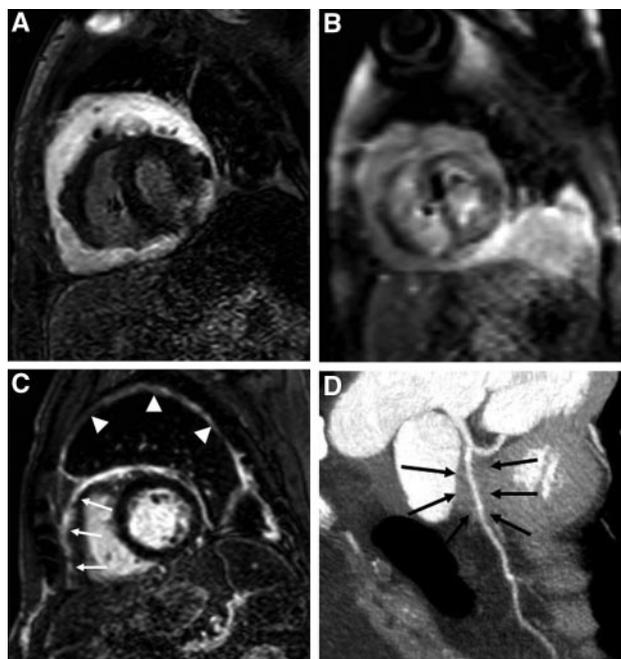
A, Late-enhancement cardiac MRI shows strong enhancement of both thickened pericardial layers. B, Still of short-axis real-time movie MRI during operator-guided breathing shows septal flattening during onset of inspiration, demonstrating pericardial constriction. C, Late-enhancement cardiac MRI shows strong enhancement of both thickened pericardial (white arrows) and pleural layers (white arrowheads). D, Curved planar reformation of a 64-detector computed coronary angiography shows large soft-tissue mass surrounding the proximal part of the left anterior descending artery (black arrows).
